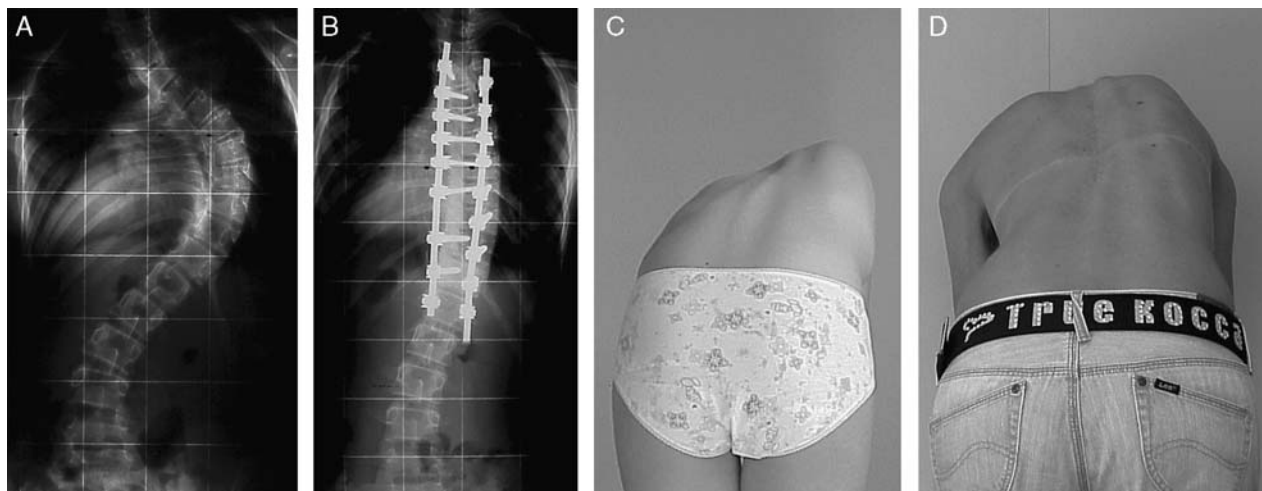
A 12.5 years old female with a Lenke 2AN curve, operated on by means of a T4-L1 pedicle screws posterior spinal fusion without thoracoplasty. Clinical and radiographic results at 6 years from the index procedure.
